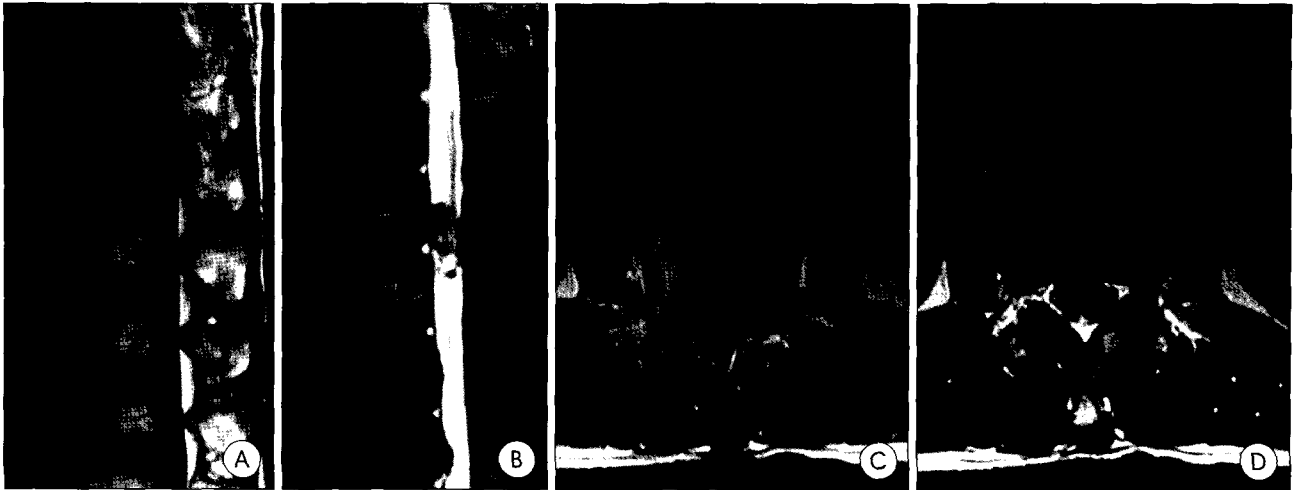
Preoperative magnetic resonance images showing a heterogeneous non-enhancing mass obliterating the spinal canal at the L2 level. The lesion exhibited a mixed signal intensity on T1(A, C) and T2(B, D) weighted images and was surrounded by dark hemosiderin ring suggesting multiple stage hemorrhage.
